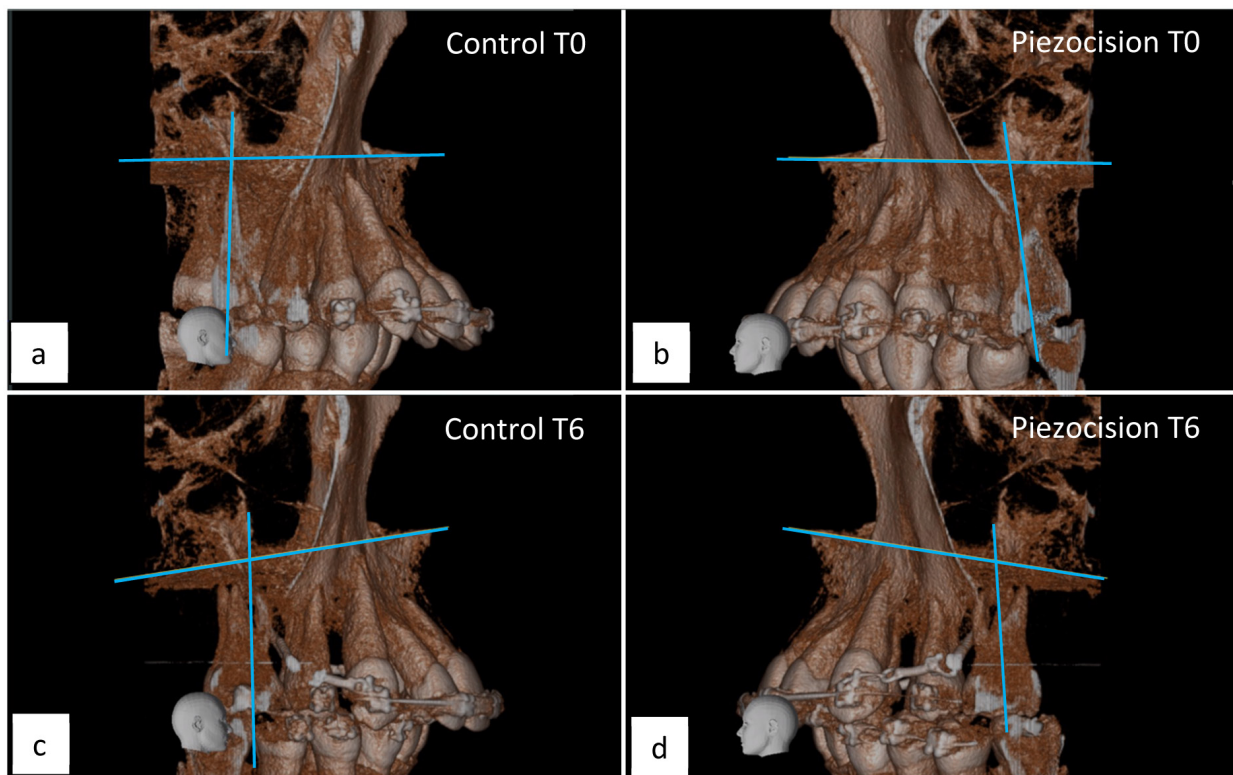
Measurement of molar tipping from CBCT images, using the angle between the long axis of the U6 to the palatal plane, control side at T0 and T6 (a,c) and piezocision side at T0 and T6 (b,d).
